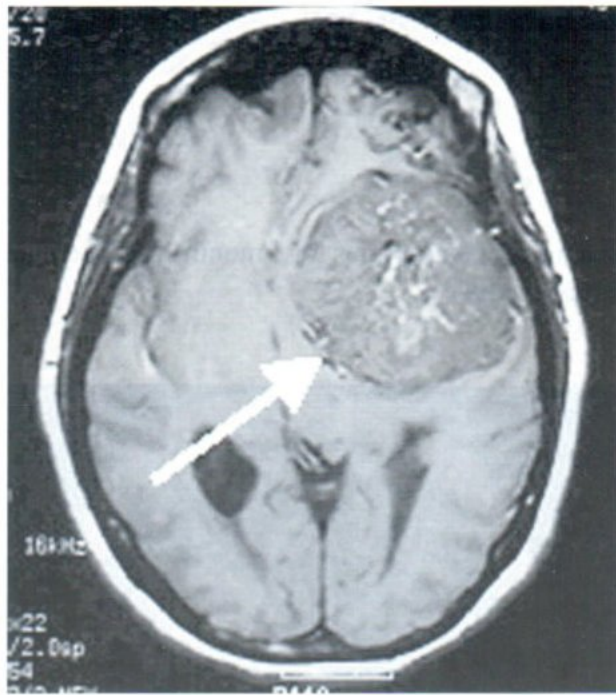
C $T_1 W_1$, non-contrast MRI shows detail content of the mass in the fronto-temporal region.
